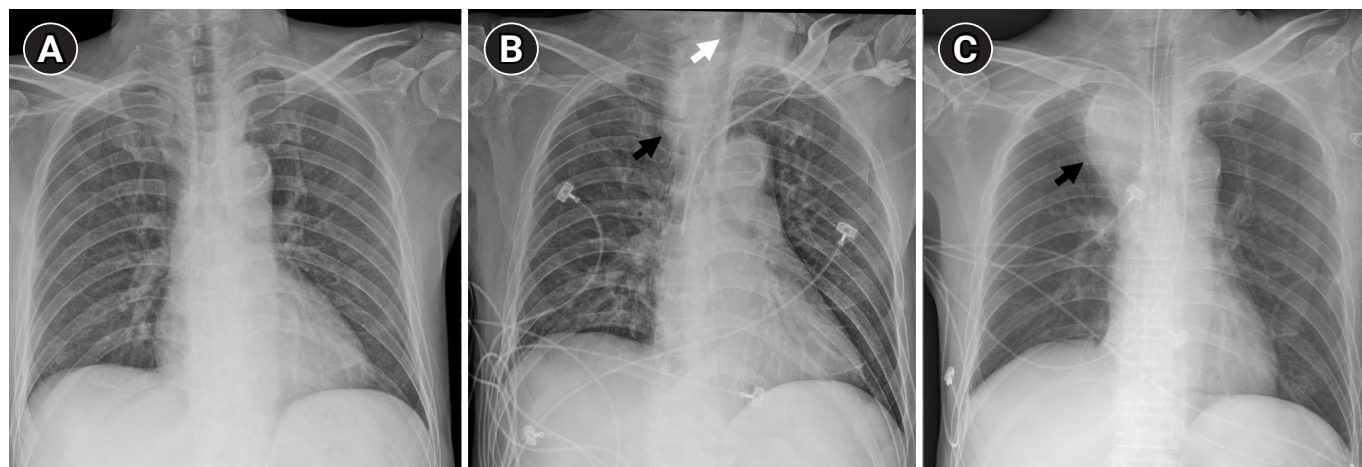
(A) Chest X-ray taken before carotid endarterectomy (CEA) shows normal findings. (B) Chest X-ray taken during dyspnea after CEA shows soft tissue swelling (black arrow) with tracheal deviation (white arrow). (C) Chest X-ray taken the day after intubation shows aggravation of soft tissue swelling (black arrow).
